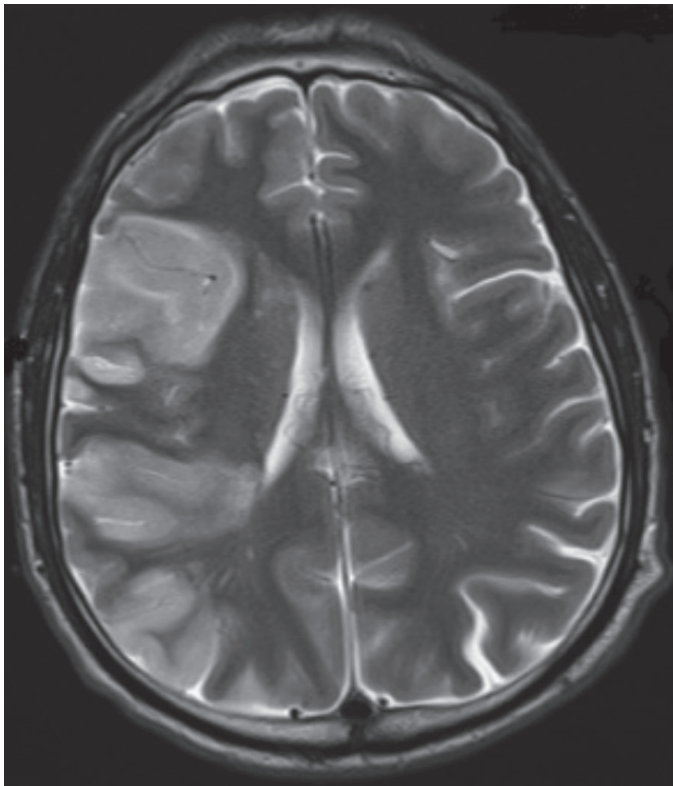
Magnetic resonance image of sub-acute infarction in the right middle cerebral artery shed area
